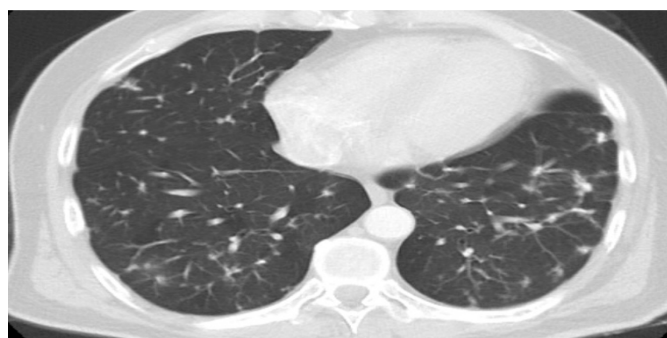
This image shows an example of "nodular infiltration" in a chest CT scan of a patient with NTM
